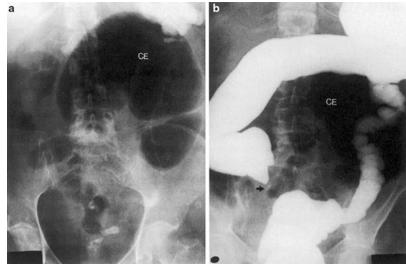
(a) Cecal volvulus, plain radiograph, *CE* cecum. (b) Barium enema. *Arrow* indicates the point of obstruction, *CE* cecum [1]
